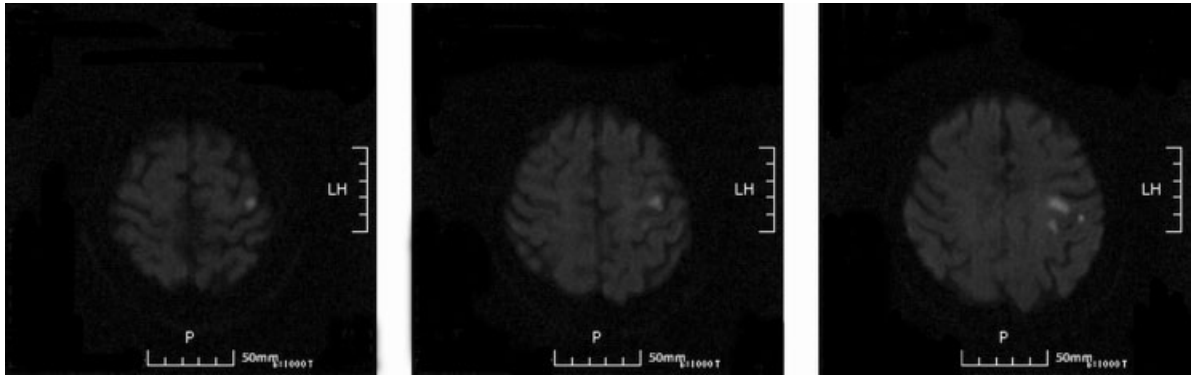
Diffusion-weighted magnetic resonance imaging of the patient. The infarction is seen adjacent to the left frontal precentral region.
